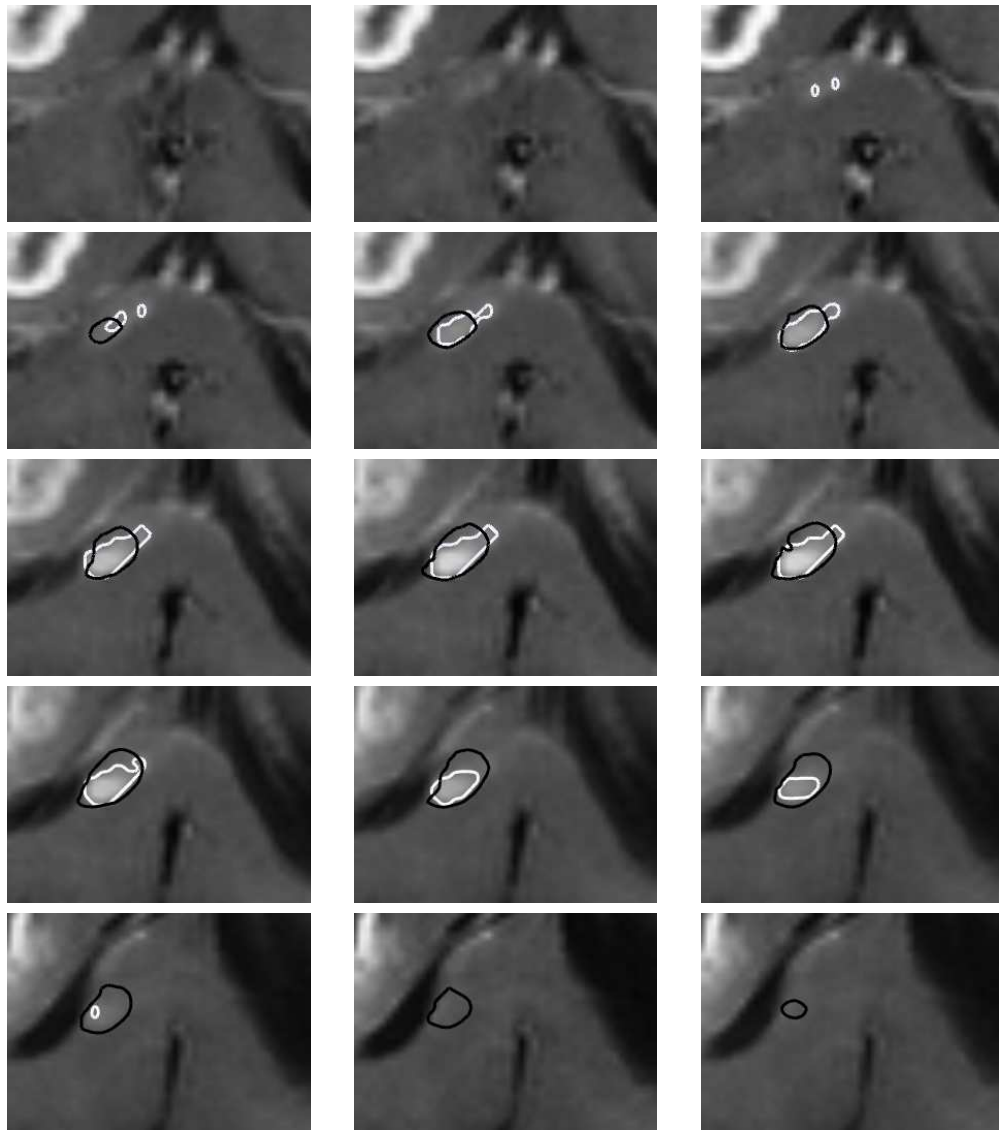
The MR image taken at the second time point for the first patient. The white contour denotes the manual delineations and the black contour is the estimated evolution of the tumor delineation.
